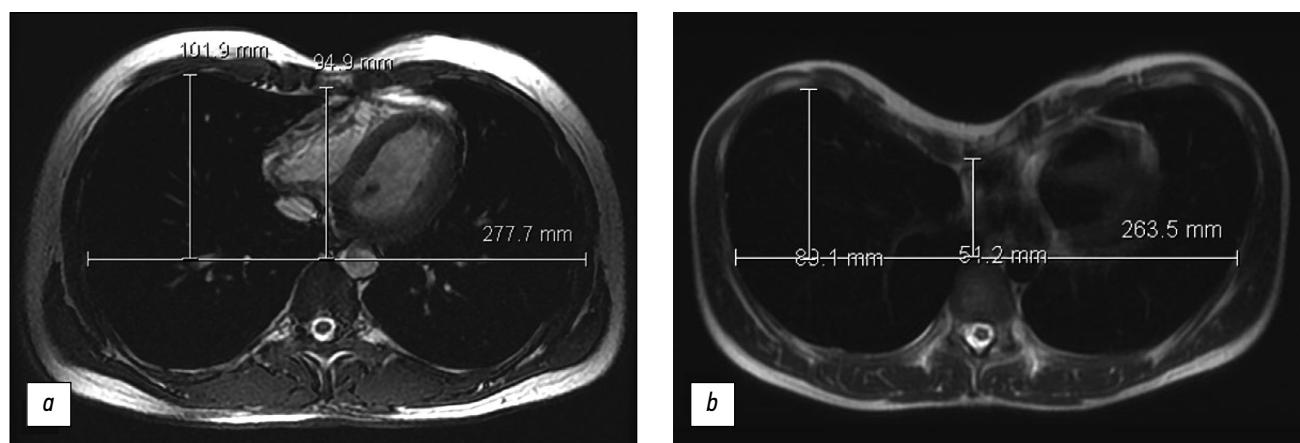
Chest magnetic resonance imaging at the level of maximum deformity; (a) the Haller index of 3.1; (b) the Haller index of 3.3; (c) the Haller index of 5.2.
